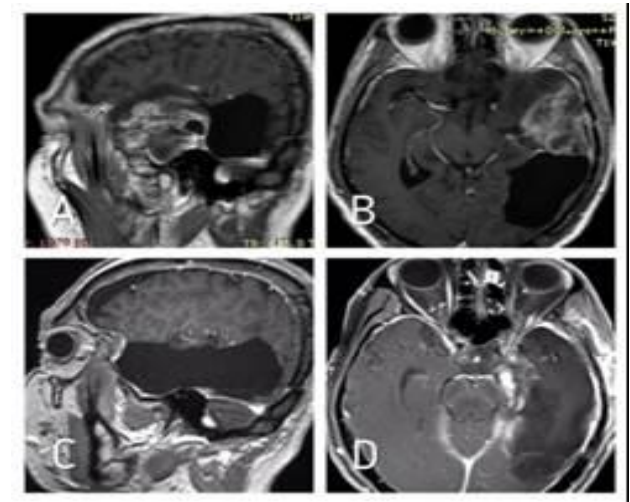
A, B: MRI of the patient in the third postoperative year showing newly formed temporal lesion.
